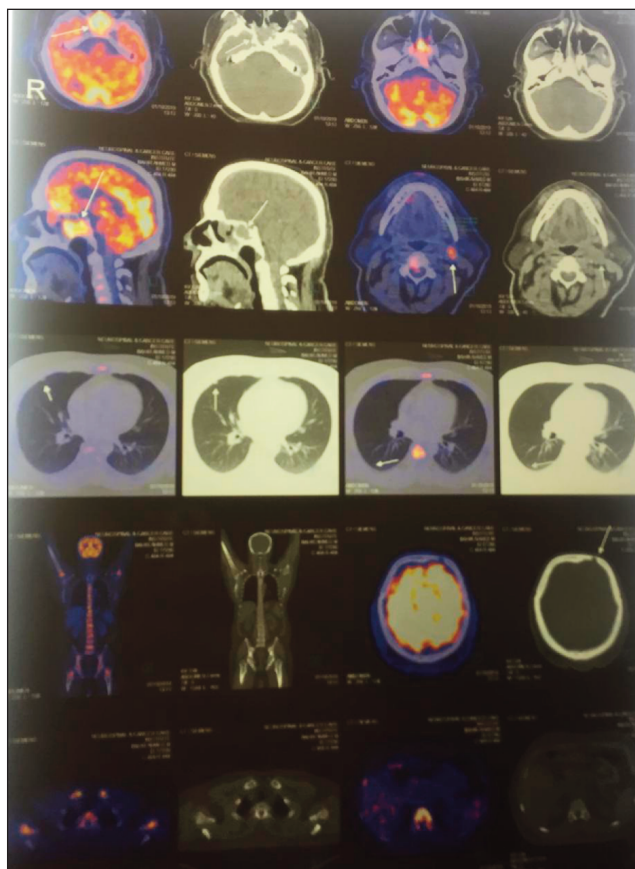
PET SCAN revealed evidence of FDG avid soft tissue thickening, seen in the sphenoid sinus.
